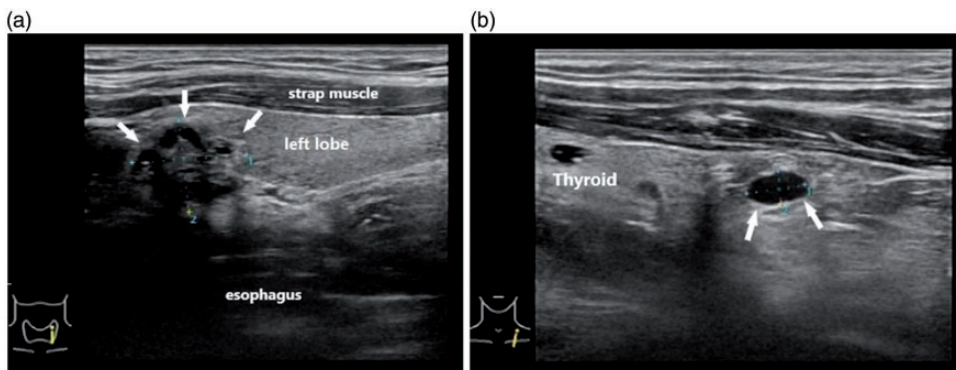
(a) Ultrasonography in the longitudinal plane showing a 12-mm nodule at the uppermost part of the left thyroid gland (arrows). (b) An oval nodule inferior to the thyroid gland measuring $5.4 \times 3.4 \text{ mm}^2$ with well-defined boundaries and homogeneous echo (arrows).
